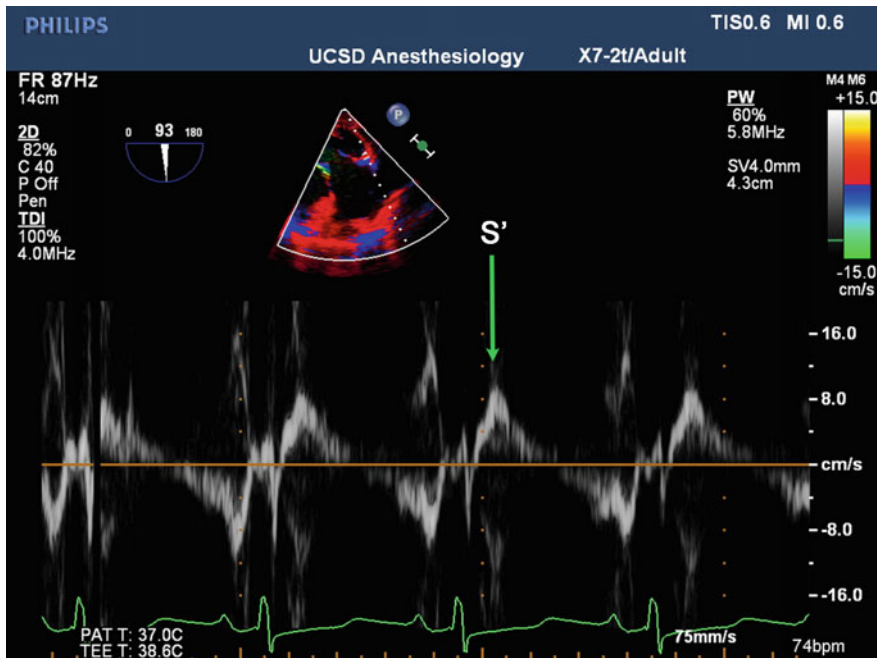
Pulsed wave tissue Doppler imaging of the basal right ventricular myocardium in a modified transgastric right ventricular inflow view. Peak tricuspid annular velocity (S') is identified by the *green arrow*
